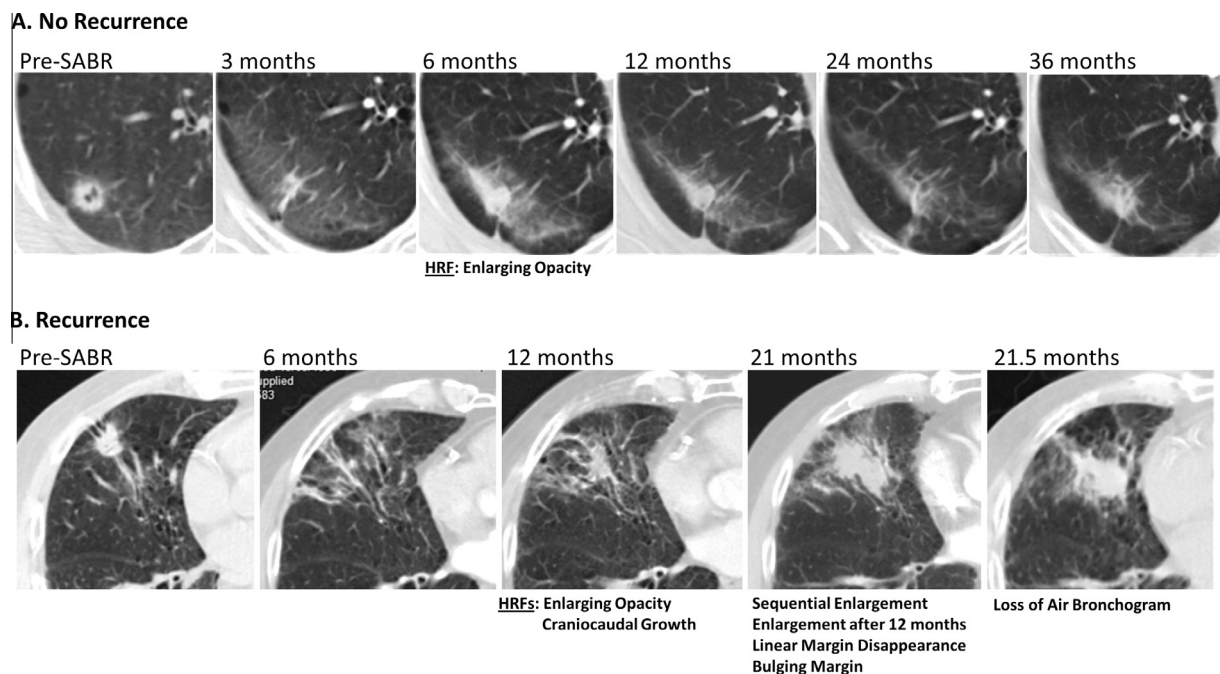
Representative CT images of patients following SABR with benign and high-risk CT features. New high-risk features (HRFs) noted in each scan specified. (A) Patient without local recurrence. A 3 month follow-up scan post-treatment shows diffuse ground glass opacity; a 6 month scan shows a high-risk CT feature: enlarging opacity; however 12, 24 and 36 month scans all show modified conventional pattern of late fibrosis with no additional high-risk CT features. No evidence of local recurrence is seen at 3 years post-treatment. (B) Patient with pathology-proven local recurrence. A 6 month follow-up scan shows diffuse consolidation; a 12 month scan shows modified conventional pattern of late fibrosis and two high-risk CT features: enlarging opacity and craniocaudal growth (latter not shown); subsequent scans show additional high-risk CT features: sequential enlargement, enlarging opacity after 12 months, linear margin disappearance, bulging margin, followed by loss of air bronchogram. Local recurrence was clinically diagnosed at 22 months and the patient underwent salvage lobectomy at 23 months.
